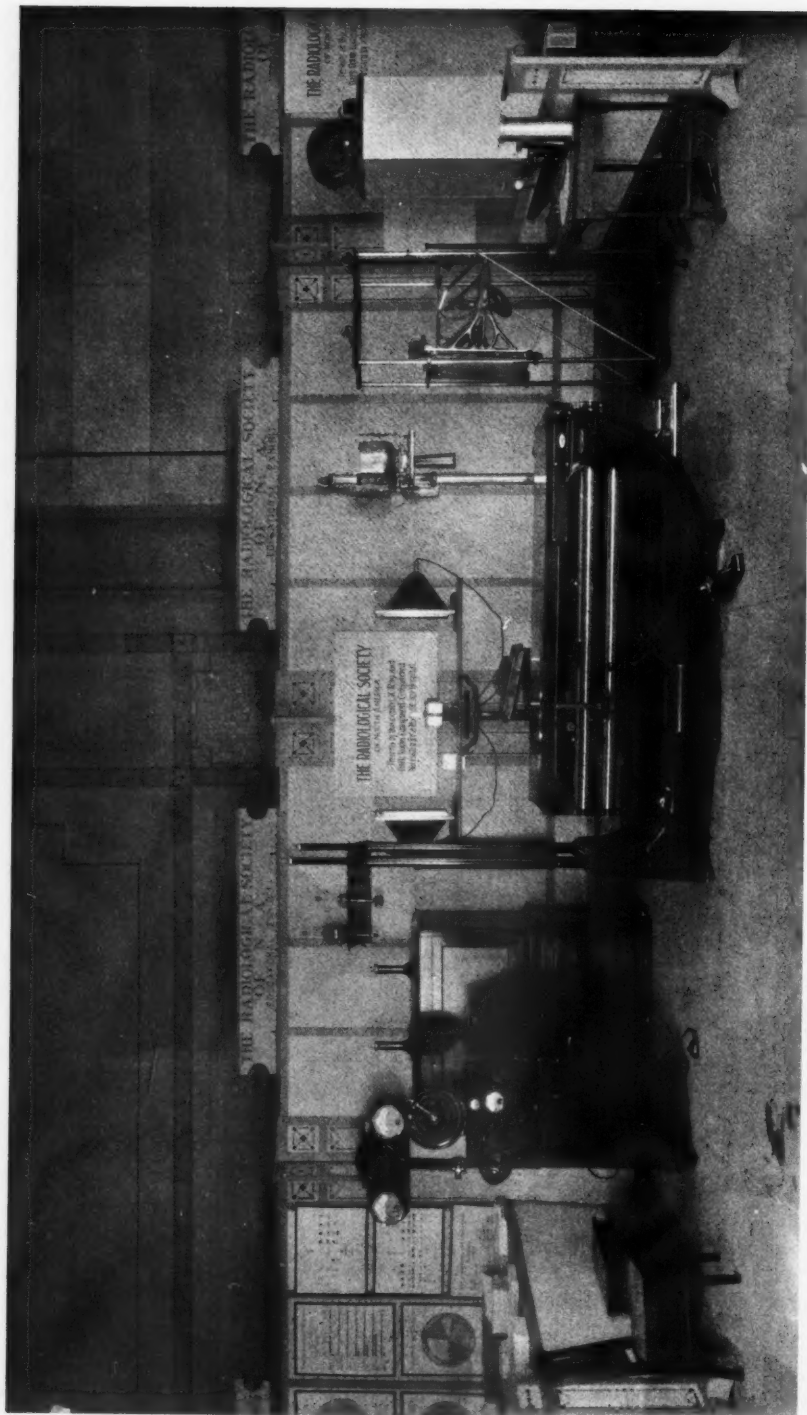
An educational exhibit, demonstrating a fully equipped X-ray department for a hospital of moderate size, presented by invitation at the New Orleans (1930) meeting of the American Hospital Association, by the Radiological Society of North America. See Figure 2 for further description. The success of this exhibit was the result of the co-operation of Dr. Robert J. May, then President of the Society, and Dr. I. S. Trosler, Secretary and Treasurer, and the valuable assistance of one of our prominent X-ray manufacturers, who generously loaned the apparatus without any display of advertising matter.
